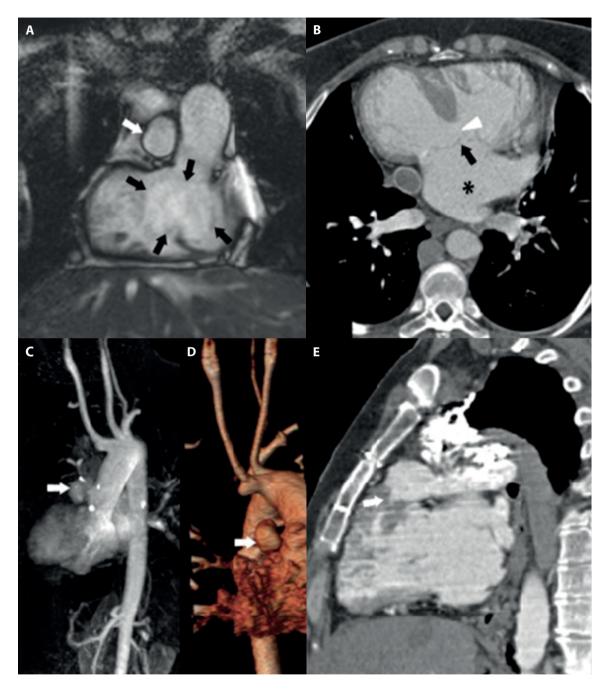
Coronal b-SSFP image (a) shows the sing le ventricle and the common atrioventricular valve (black arrows). Axial CT scan (b) shows the large ventricular septal defect (arrowhead) and the common atrium (*) with common atrioventricular valve (black arrow). Maximum intensity projection (MIP) (c) and volume rendering techniques (VRT) (d) reconstruction of CE-MRA and sagittal CT scan (e) show the double outlet left ventricle with ascending aorta and origin of pulmonary artery (white arrow in a,c,d,e).
